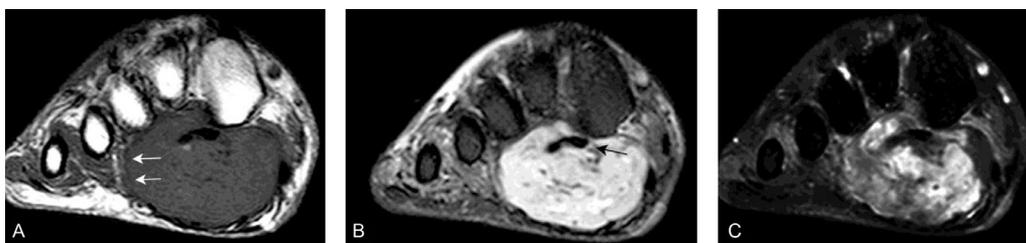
Synovial sarcoma. (A) Coronal short-axis T1WI shows a large lobulated deep-seated mass in the foot. The lesion has slightly ill-defined margins at the lateral aspect (white arrows). (B) Coronal short-axis fat saturated T2WI shows hyperintense signal intensity. There are hypointense foci in keeping with calcifications (black arrow). (C) On coronal short-axis postcontrast fat saturated T1WI, the mass demonstrates heterogeneous enhancement. T1WI, T1-weighted images; T2WI, T2-weighted images.
